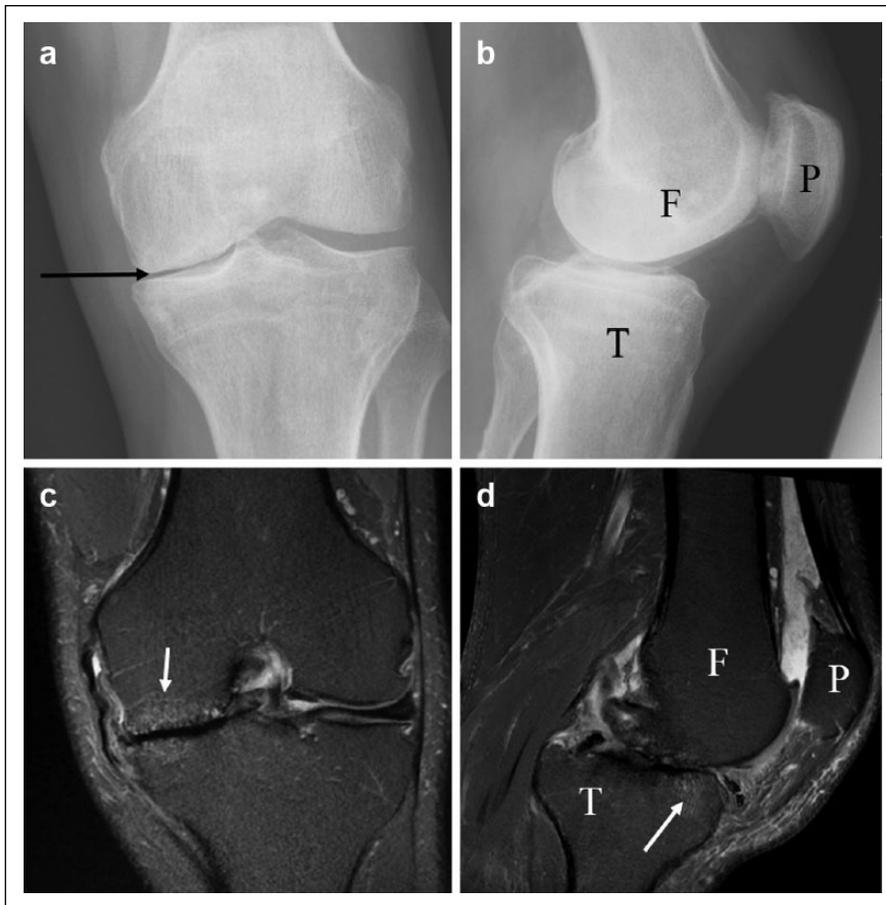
Radiographic and magnetic resonance (MR) images of the left osteoarthritic knee from a person with OA. The anterior-posterior (AP) projection radiograph (a) shows a narrowed medial tibiofemoral joint space (black arrow), whereas abnormalities are less apparent in the lateral view (b). In the MR images, bone marrow lesions can be seen in both (c) AP and (d) sagittal images (white arrows). F = femur; T = tibia; P = patella. Image credit: T. Kurien.
